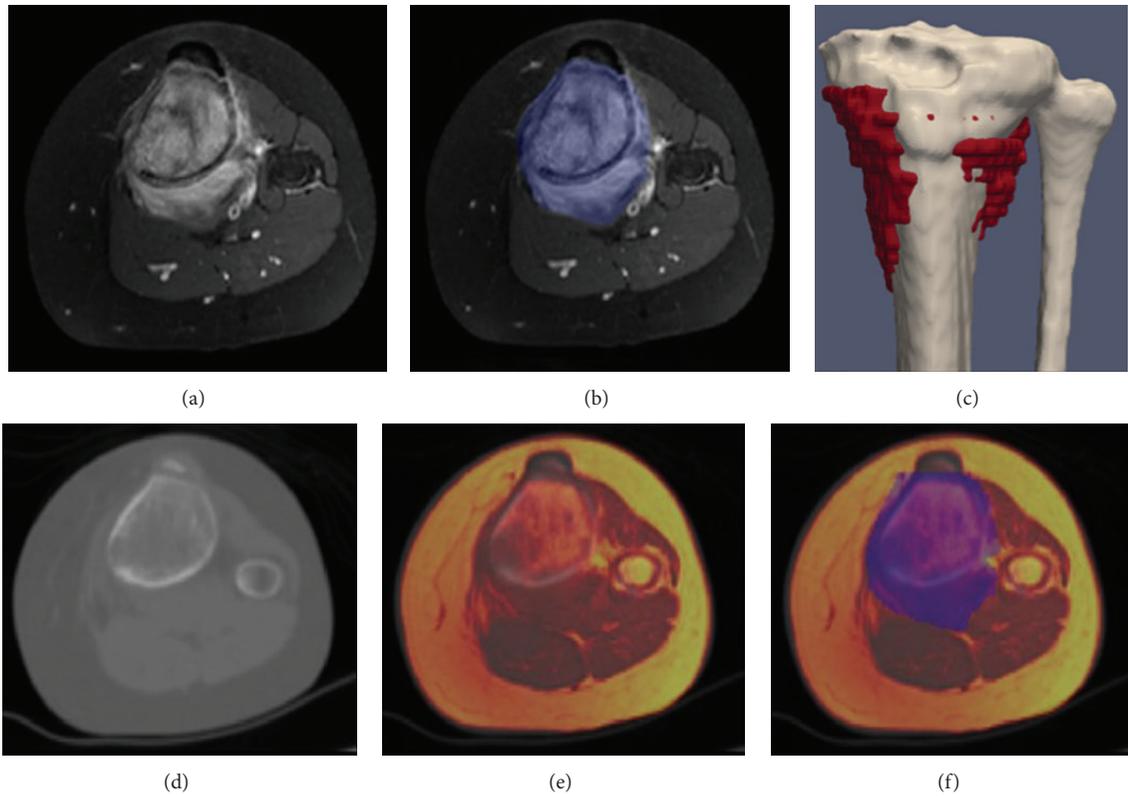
11-year-old patient with tibia metastasis of a femoral osteosarcoma. (a) MRI showing the osteosarcoma invading the proximal tibia. (b) Tumor is delineated in blue on each slice of MRI where it is visible. (d) CT scan. (e) Merging of MRI and CT. (f) MRI-CT merging with the delineation of the tumor. (c) 3D reconstruction of the tibia with the delineated tumor visible (red).
